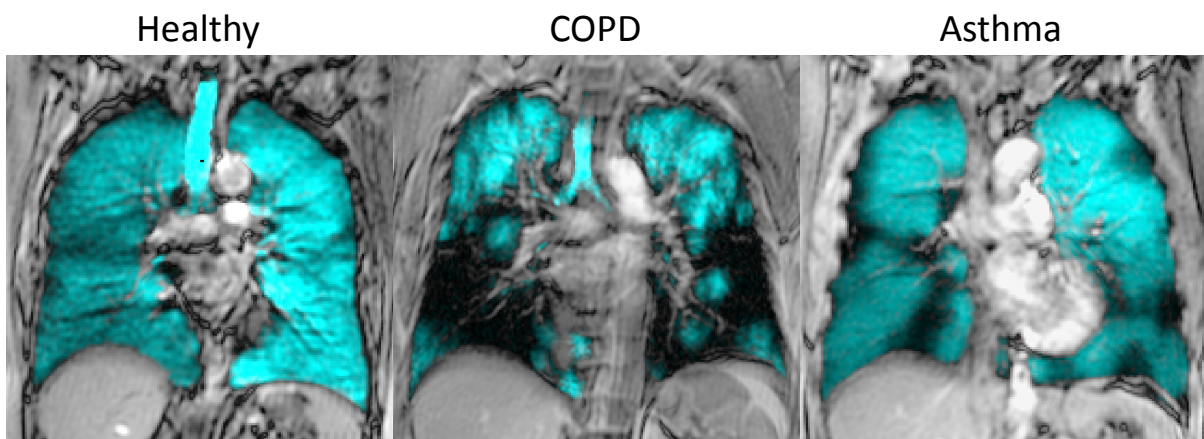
Representative co-registered hyperpolarized  $^3\text{He}$  (cyan) and  $^1\text{H}$  (gray) MR coronal images of a healthy, COPD and asthma subject. Homogeneous  $^3\text{He}$  MRI signal intensities are observed in the healthy while heterogeneous signal intensities are seen in obstructive lung disease.
